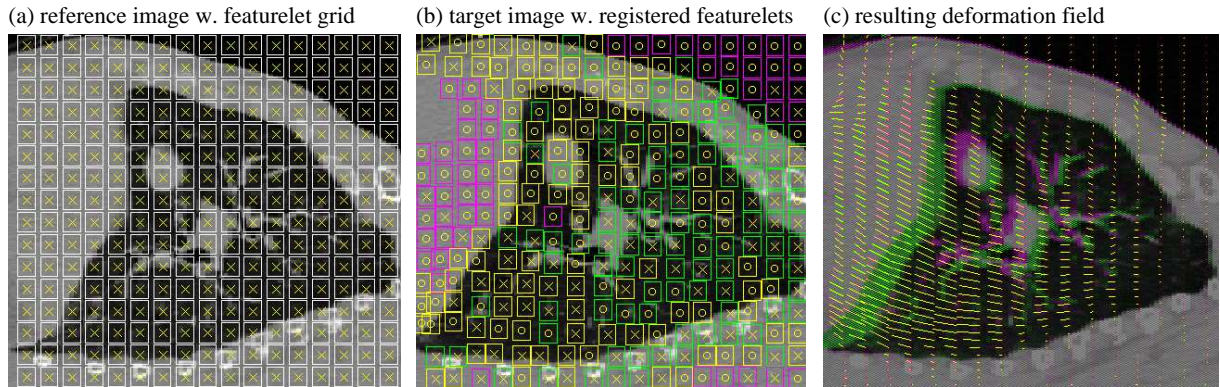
Featurelet-based deformable registration for a lung example patient (sagittal view). (a) Grid of reference featurelets in the exhale CT. (b) Registered featurelets in the inhale CT after local registration and relaxation. The colors refer to the results of the local registration quality assessment (see fig. 3.5). (c) Red-green overlay of inhale and exhale CT and the displacement field as calculated by the deformable registration algorithm.
